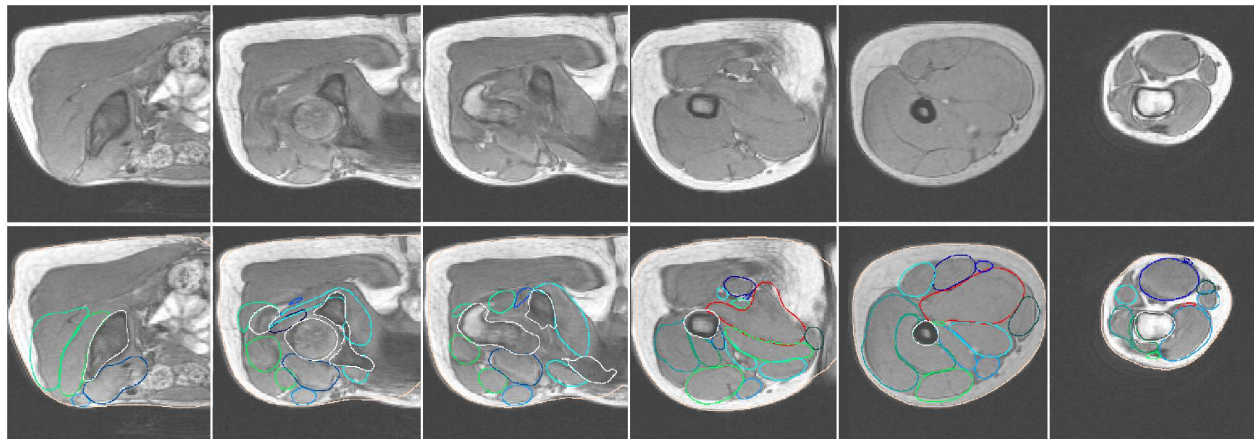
Muscle automatic segmentation from low resolution MRI
